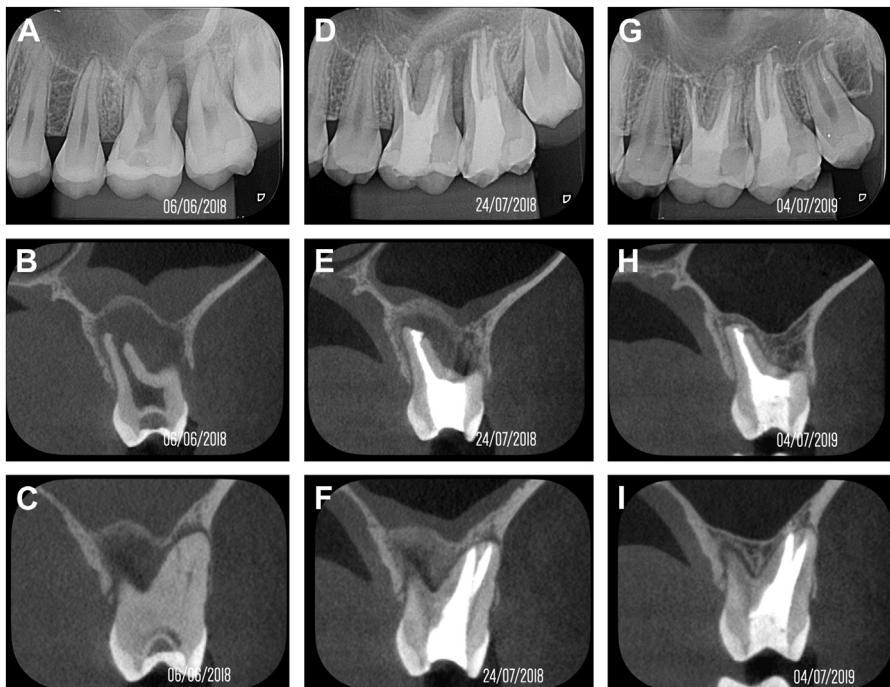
(A) Periapical radiograph, and (B, C) CBCT showing the left maxillary first and second molars with apical periodontitis and the presence of mucositis in the maxillary sinus (sinus floor reactive mucosal thickening). (D) Periapical radiograph and (E, F) CBCT taken 1 month after endodontic treatment showing partial resolution of apical periodontitis and reduction of the sinus mucosal thickening. (G) Periapical radiograph and (H, I) CBCT taken 10 months after endodontic treatment showing complete resolution of apical periodontitis and the sinus mucosal thickening. Note this was not ODS, but important to know that dental treatment alone is all that is usually necessary in these scenarios. (Courtesy of Prof. Dr. Leandro Pereira, Campinas, Brazil.)
